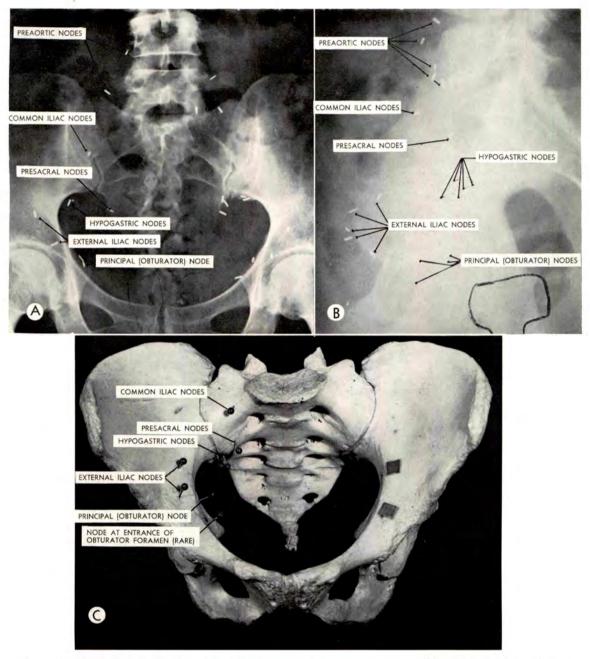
Location of pelvic lymph nodes. (A) Anteroposterior roentgenogram of the pelvis, with lymph node locations identified by metallic clips attached during lymphadenectomy. The colpostats have been traced in the same relative position to the bony pelvis as they were on the roentgenograms taken with the applicators in situ. (B) Lateral roentgenogram of the pelvis of the same patient. Because of a small senile vagina, the vaginal applicators are low in relationship to the lymph nodes. (C). Dry pelvis with pins located at the position of the lymph nodes as determined from roentgenograms. (Reproduced with permission of Radiology.\*)
